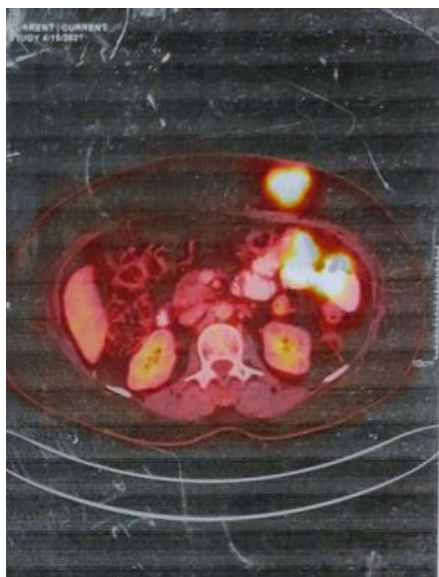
PET-CT image showing hypermetabolic soft tissue nodule on the anterior abdominal wall and on the lesser curvature of stomach
